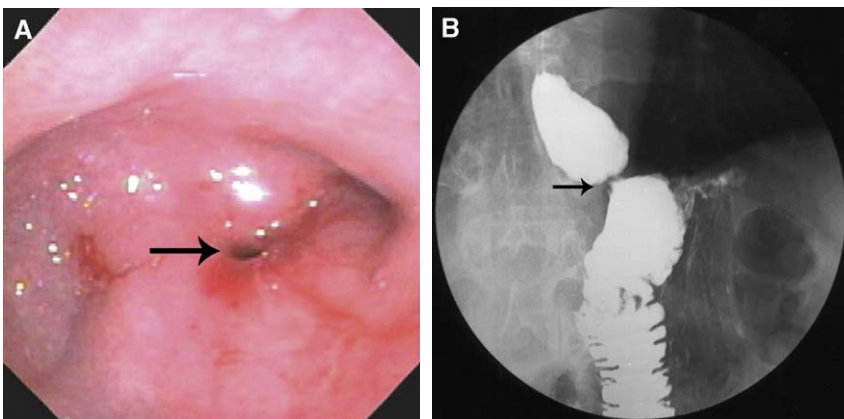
(A) Endoscopic appearance of significant stomal stenosis after gastric bypass, resulting in a pinpoint stoma (arrow). (B) Radiographic appearance of stomal stenosis after gastric bypass (arrow).
